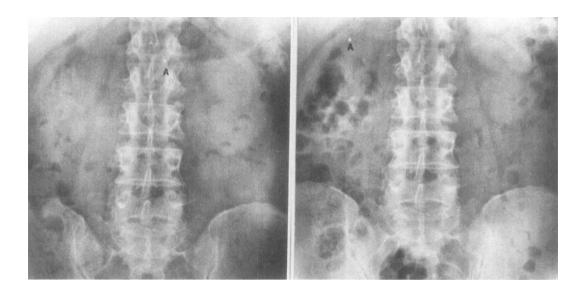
Gastrointestinal transit of two sustained-release film-coated tablets under non-fasting conditions. Drug dosing (A) at 8 a.m. and (B) at 2 p.m. Timing of the X-rays: 2,4 ,8, 12 and 24 h after ingestion of Tablet A.
